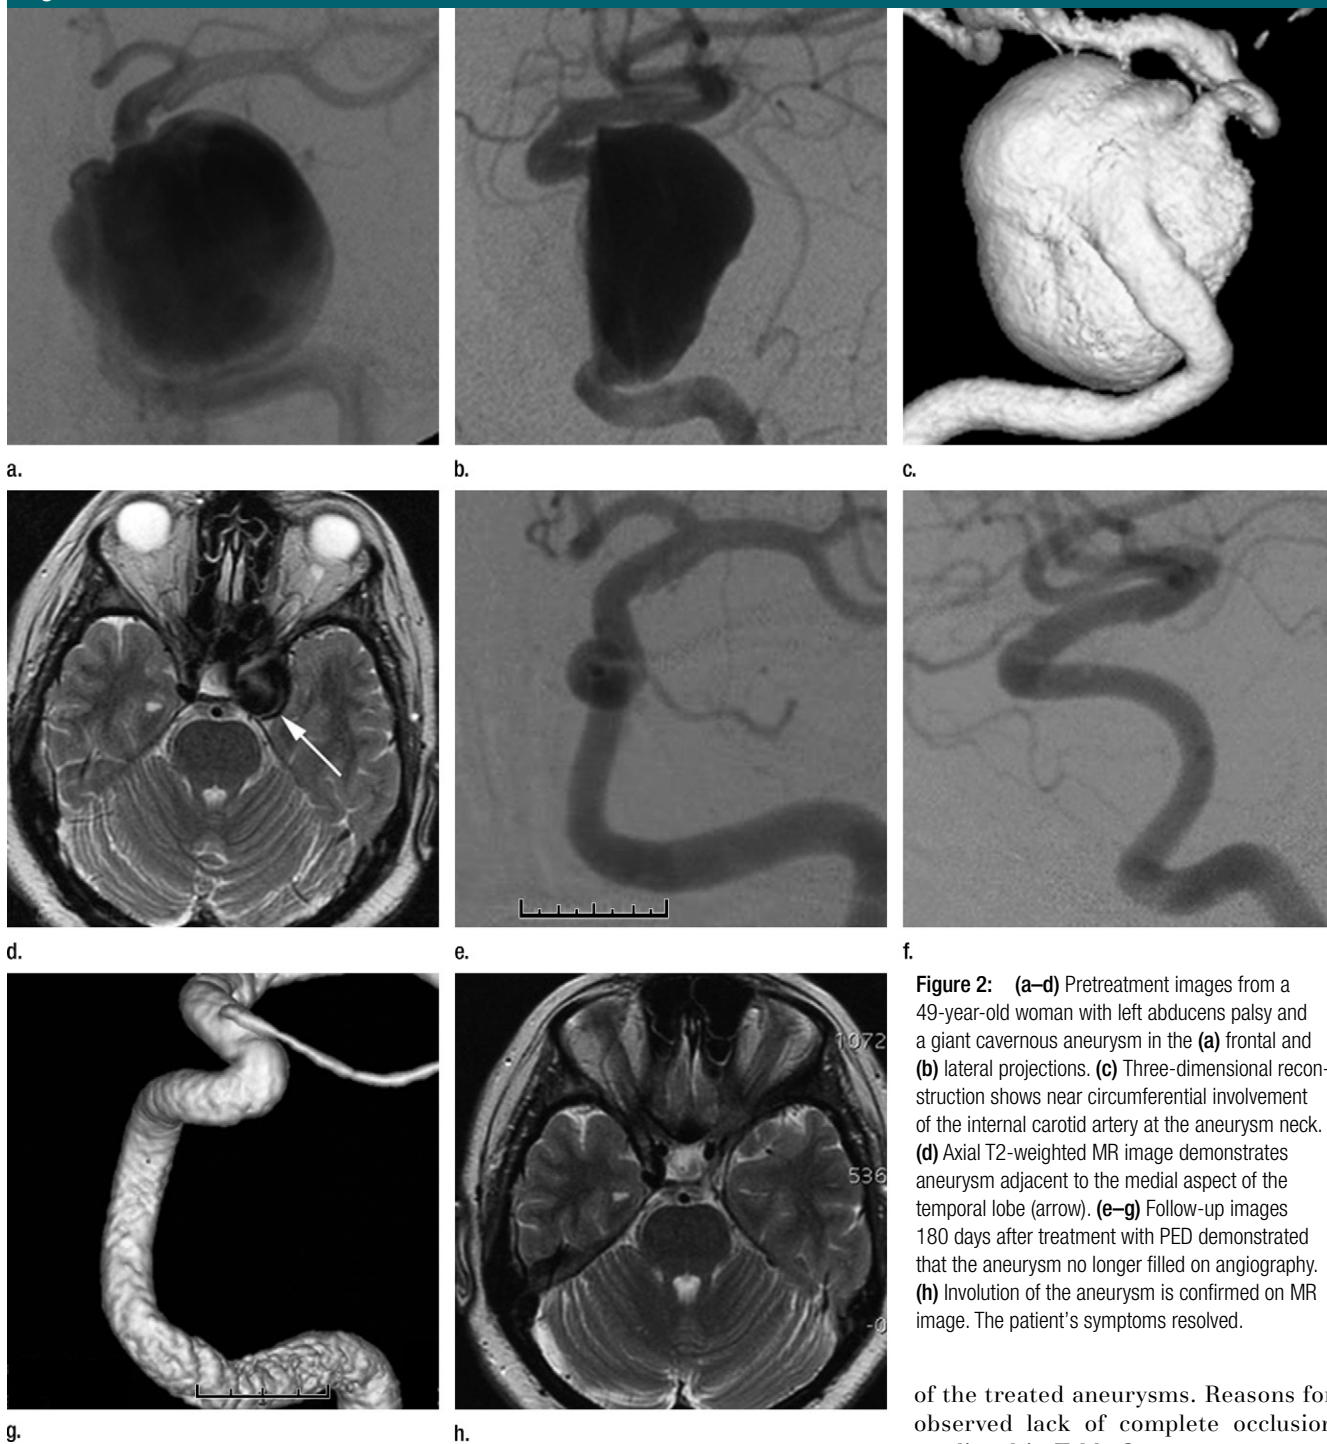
(a–d) Pretreatment images from a 49-year-old woman with left abducens palsy and a giant cavernous aneurysm in the (a) frontal and (b) lateral projections. (c) Three-dimensional reconstruction shows near circumferential involvement of the internal carotid artery at the aneurysm neck. (d) Axial T2-weighted MR image demonstrates aneurysm adjacent to the medial aspect of the temporal lobe (arrow). (e–g) Follow-up images 180 days after treatment with PED demonstrated that the aneurysm no longer filled on angiography. (h) Involution of the aneurysm is confirmed on MR image. The patient’s symptoms resolved.
